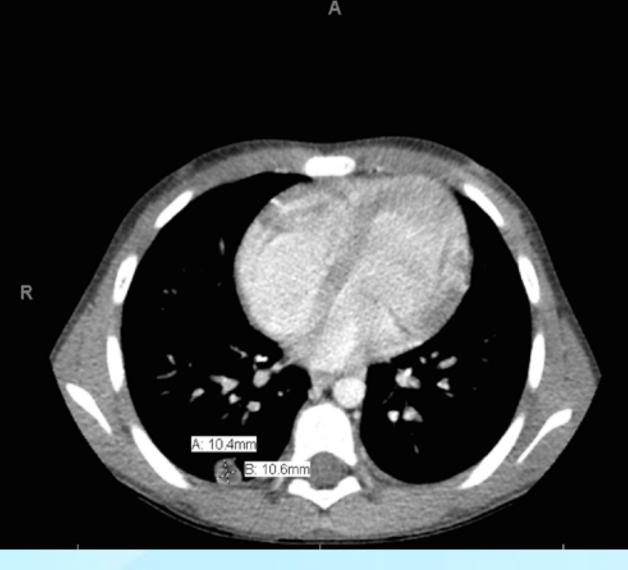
CT Chest: Cystic Lesion to R lung.
